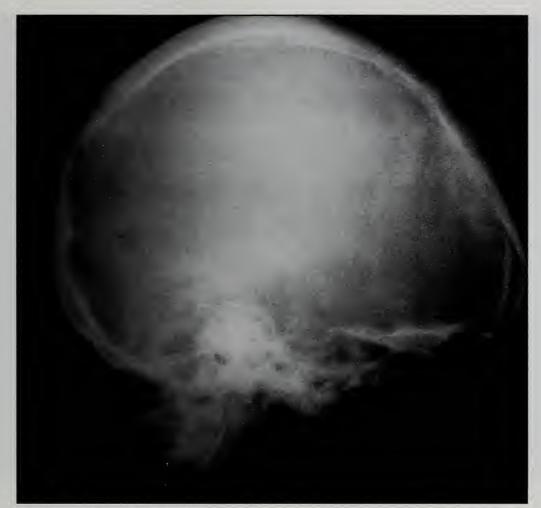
The skull radiograph demonstrates a single "punched out" lytic lesion in the occipital region.
